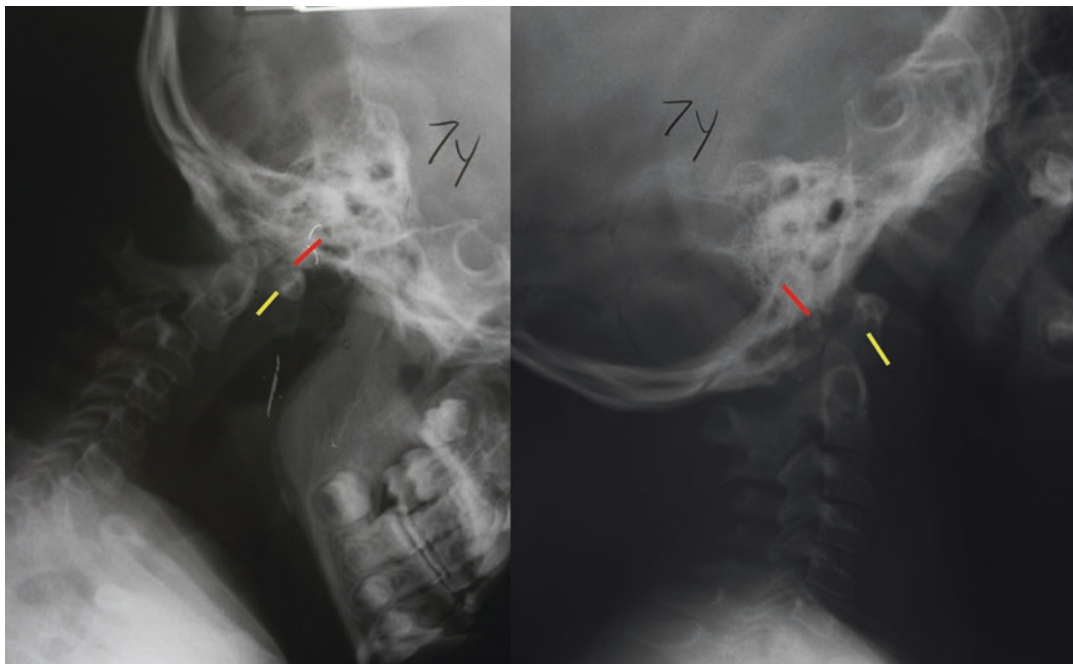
Occipital-C1 instability in a 7-year-old patient on flexion/extension radiographs. On extension, the skull moves posterior (red line), relative to the posterior edge of the C1 arch (yellow line)
